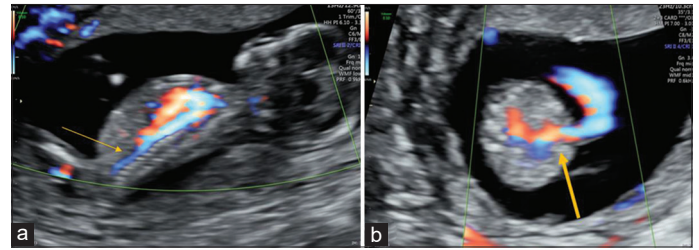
(a) ultrasound color Doppler in sagittal view. Arrow showing hypoplastic distal aorta; (b) ultrasound colour Doppler in axial view. Arrow showing single umbilical artery in a cranial location
